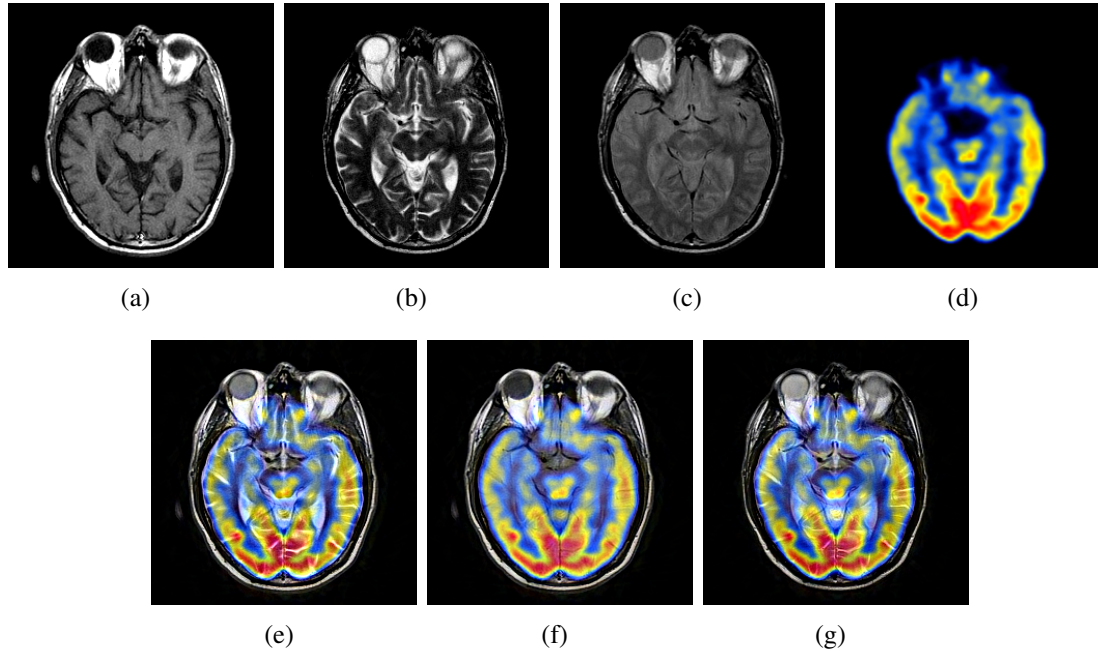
Multimodal fusion of three 2-D real neuroimages (MR-PET combinations) of a mild Alzheimer's disease patient from the Whole Brain Atlas database. (a) MR-T1 image. (b) MR-T2 image. (c) MR-PD image. (d) FDG-PET image. (e) Fused image of (a), (b), and (d). (f) Fused image of (a), (c), and (d). Fused image of (b), (c) and (d). NOTE: Figs. 3.21 (a), (b), and (c) are, respectively, the same as Figs. 3.17 (a), (b), and (c), and are repeated here for convenience.
